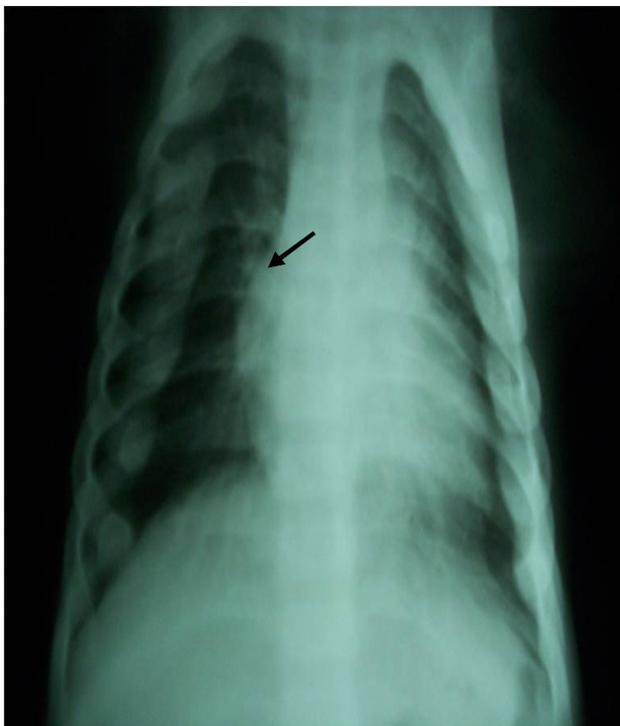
Chest X-Ray PA View Shows Rachitic Changes in the Ribs
